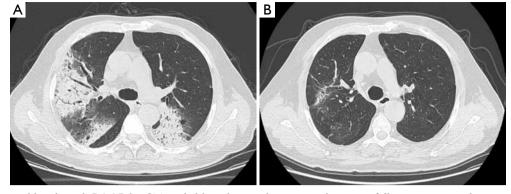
A 45-year-old male with BOOP by CT-guided lung biopsy showing resolution on follow-up computed tomography (CT) scans. (A) Chest CT showing bilateral alveoli filled with consolidation and ground glass opacities; (B) chest CT at the same level after 3 months of glucocorticoid treatment, showing bilateral blotchy consolidation, ground glass opacities absorbed strips and traction bronchiectasis. BOOP, bronchiolitis obliterans organizing pneumonia.
